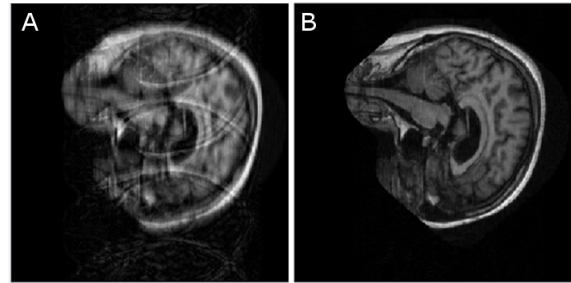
Example result of our technique on sagittal brain MRI. (A) subsampled image: 4-step, 4% low-frequency. (B) Reconstruction
